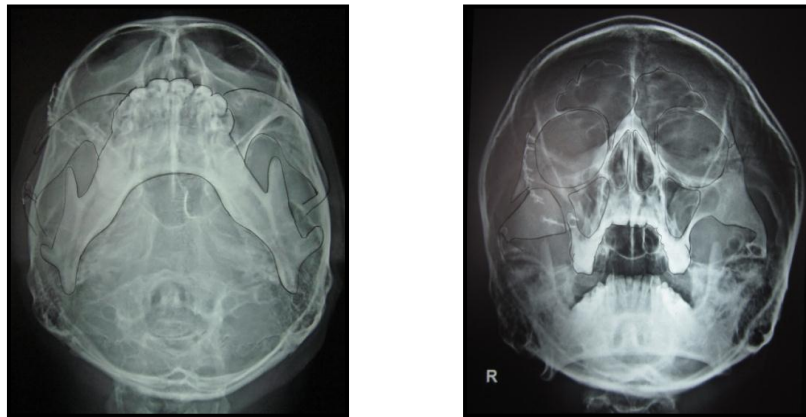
TRACING – 5TH WEEK POST OPERATIVE RADIOGRAPHS
